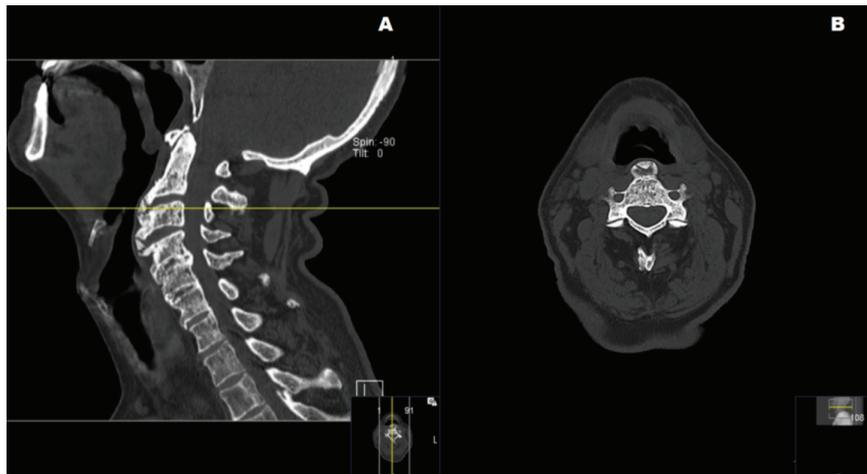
Preoperative CT images, (A) sagittal reconstruction (B) axial scan.
